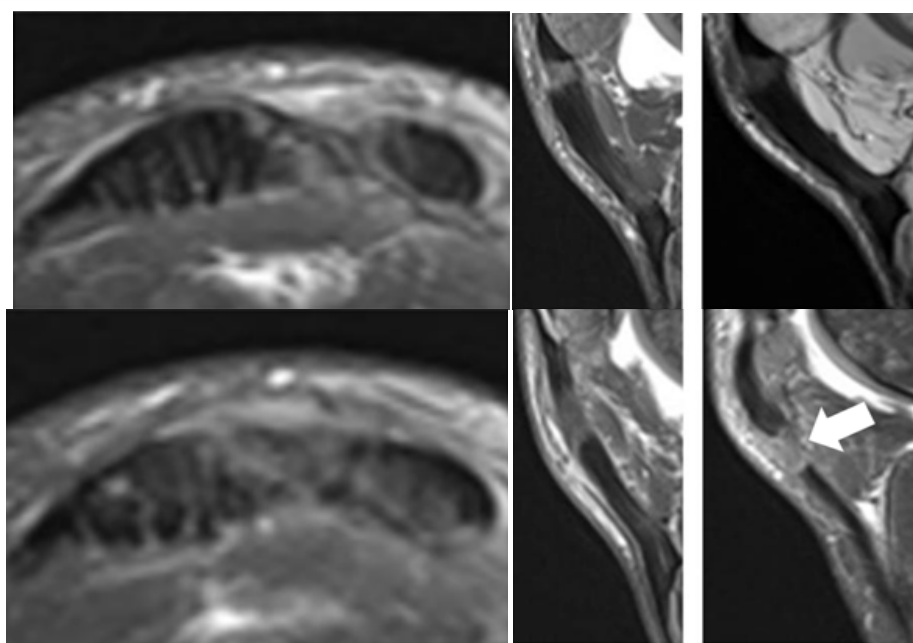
Magnified magnetic resonance imaging images in DP FATSAT axial planes; sagittal T2 FATSAT and sagittal DP where a tear of at least 70% in the patellar tendon is identified, as well as abundant joint fluid.
